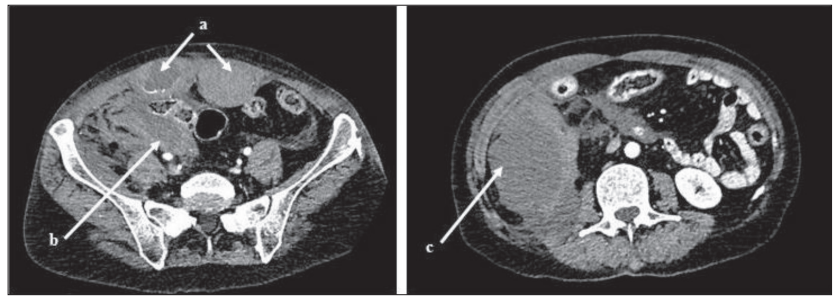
Case 2 – (a) axial computed tomography scans of the abdomen and pelvis show bilateral rectus abdominis muscles hematomas (a) extending into the extraperitoneal pelvis; another hemorrhagic collection in the right retroperitoneum with displaced adjacent structures (c)
